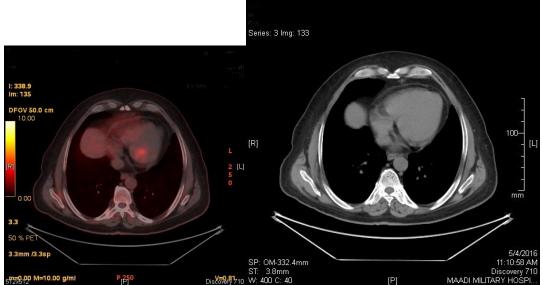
¹⁸F-FDG PET/CT shows normal FDG uptake seen in PET part of study. DISCUSSION
